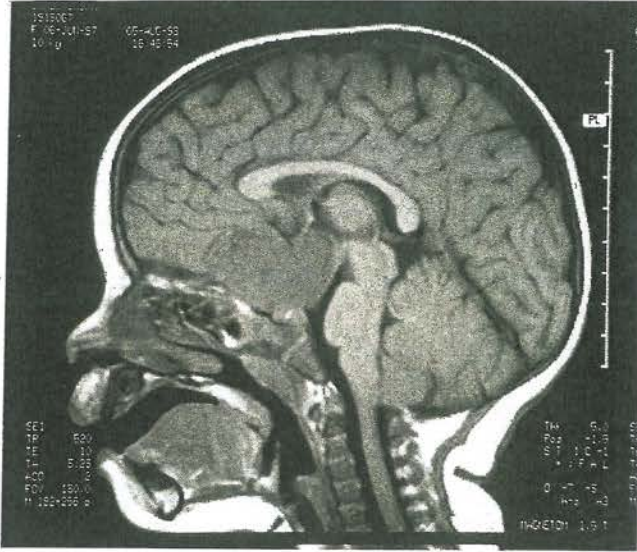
Sagittal T1-weighted MRI scan showing invasion of the hypothalamus by an optic nerve glioma in NF-1.
